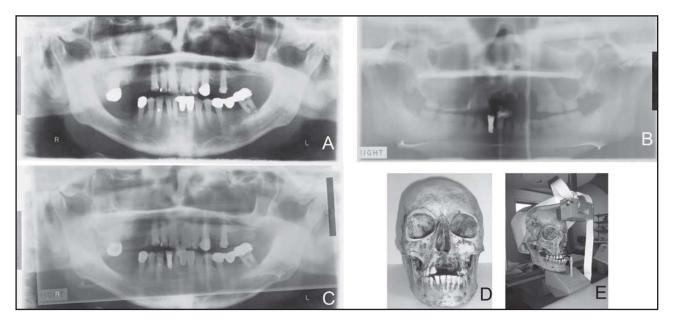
Case three. A antemortem OPG, B postmortem OPG of an acrylic mandible and skull with tooth 42 embedded in its assumed anatomical position, C superimposition of both radiographs at opacity 50% showing consistent outline of tooth 42 without resizing either image. D and E show tooth 42 embedded in the acrylic mandible during radiography
